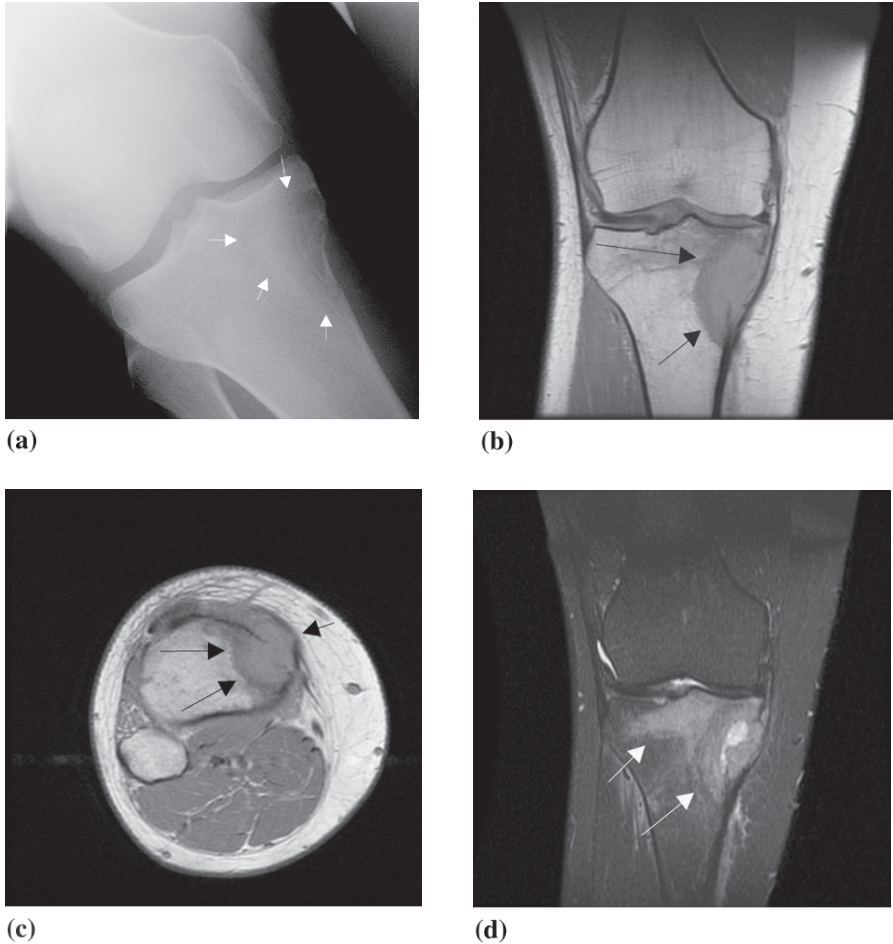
High-grade conventional osteosarcoma in a 21-year-old male presenting with knee pain. (a) Frontal radiograph of the right knee demonstrates an ill-defined lucent lesion of the proximal tibial epiphysis / metaphysis (white arrows) with medial cortical destruction. (b) Coronal and (c) axial proton density weighted and (d) coronal STIR MR images of the proximal tibia better show the extent of marrow involvement and the extraosseous extension through a violated cortex (arrows). Images courtesy of Dr. Mary G. Hochman
